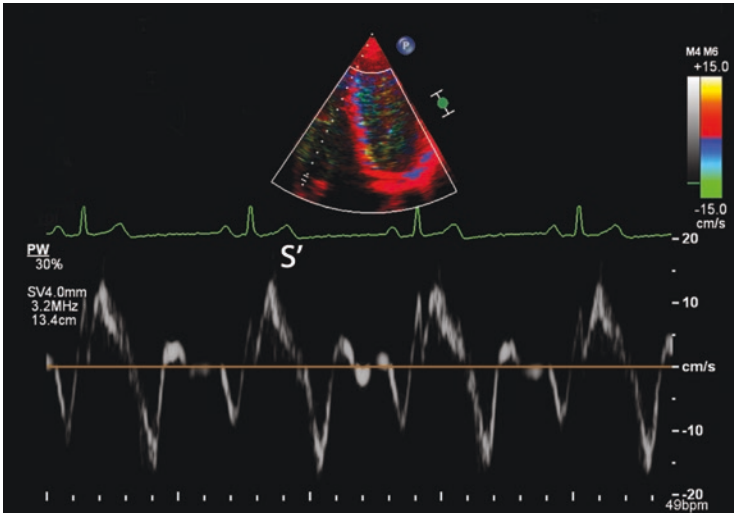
Doppler Tissue Imaging of the tricuspid annulus, measuring the velocity of tricuspid annular systolic motion in a patients with normal RV systolic function. S' velocity <9.5 cm/s measured on the free-wall side indicates RV systolic dysfunction
